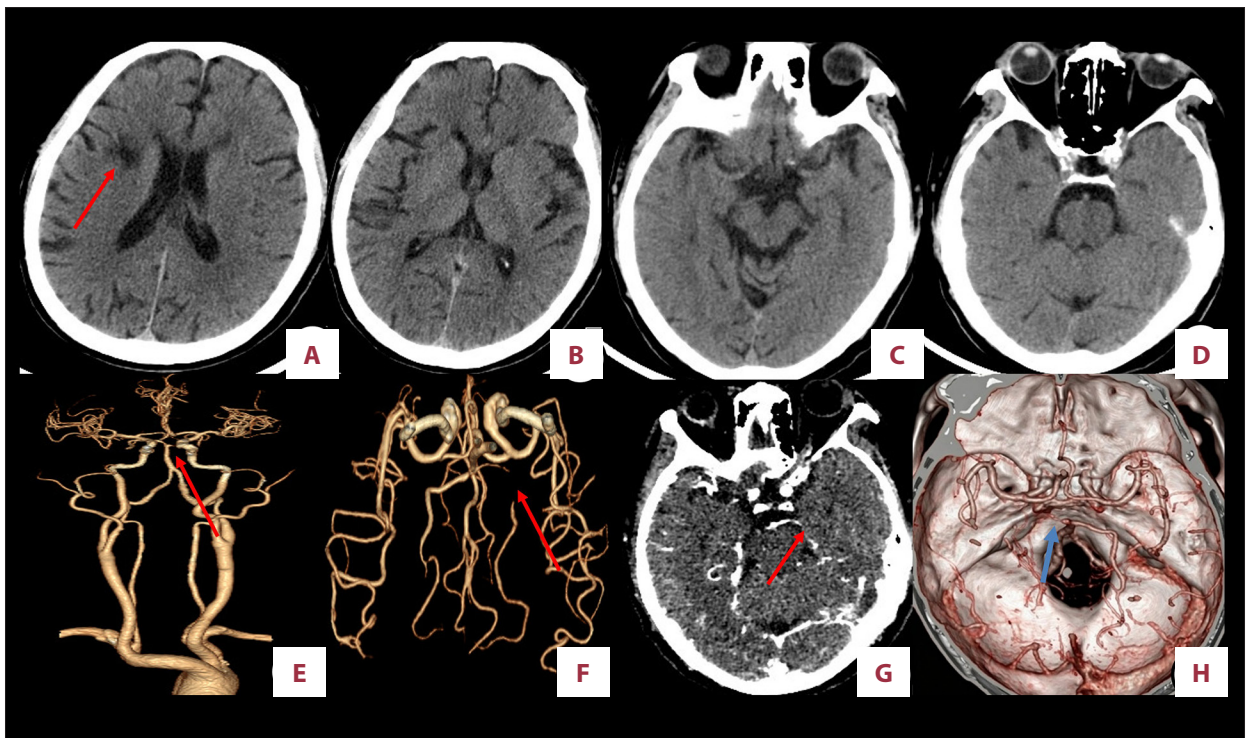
(A) The red arrow indicates a patchy low-density shadow in the right frontal lobe (considering an old infarct). (B-D) No obvious abnormal lesions were found in the bilateral thalami, midbrain, and pons. (E-H) Computed tomography angiography reveals severe stenosis to occlusion in the P1 segment of the left posterior cerebral artery.
